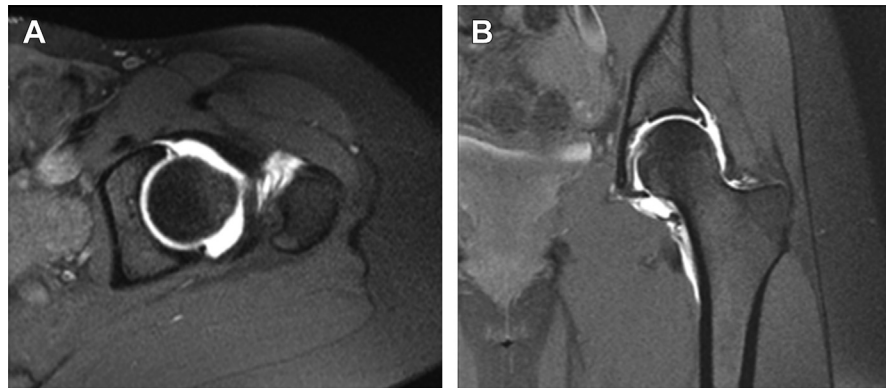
Axial (A) and coronal (B) MRI arthrogram images demonstrating an anterolateral labral tear of the left hip.
